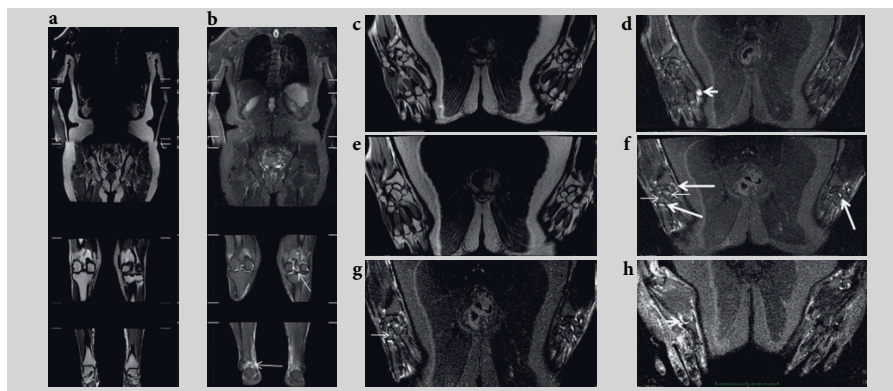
Whole-body magnetic resonance imaging (MRI) of a patient with rheumatoid arthritis. Recent MRI hardware and software allow obtaining images of the entire body head-to-toe during one scan session: whole-body MRI (WBMRI). Here, 3T WBMRI are shown. Coronal T1-weighted images without fat suppression before (a) and after (b) with fat suppression after contrast injection are shown (neck and feet are not shown). Synovitis is seen in knee and ankle joints (thin long arrows). (c–f): enlargements of coronal T1-weighted WBMRIs of the hands before (c, e) and after (d, f, with fat suppression) a contrast injection. (g, h): Coronal short tau inversion recovery (STIR) images. Synovitis is seen in both wrists (long thick arrows) and in the right second metacarpophalangeal joint (short thick arrows). Bone marrow edema (d; thin short arrows) is seen in several wrist bones.
